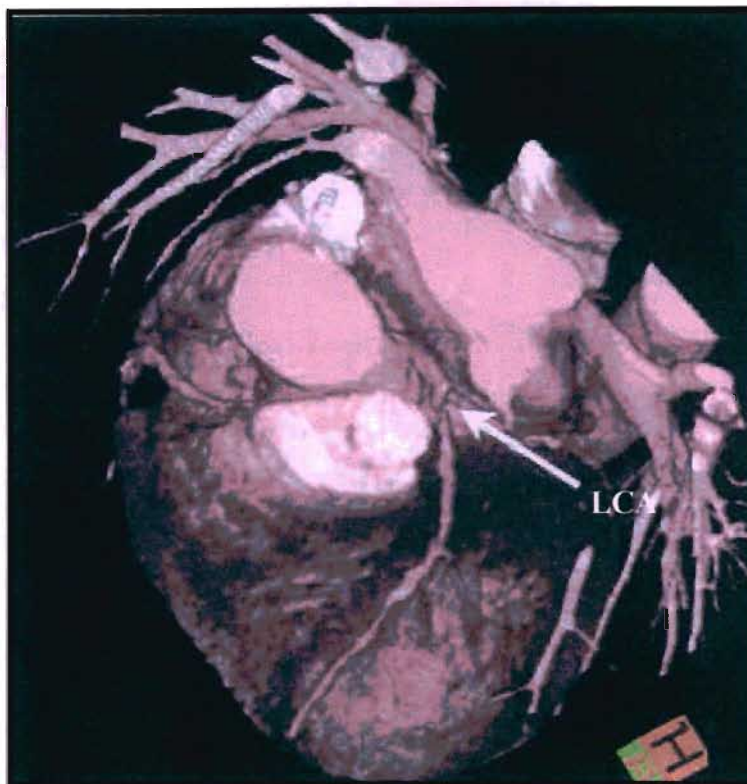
(b): CT image of the proximal coronary arteries
